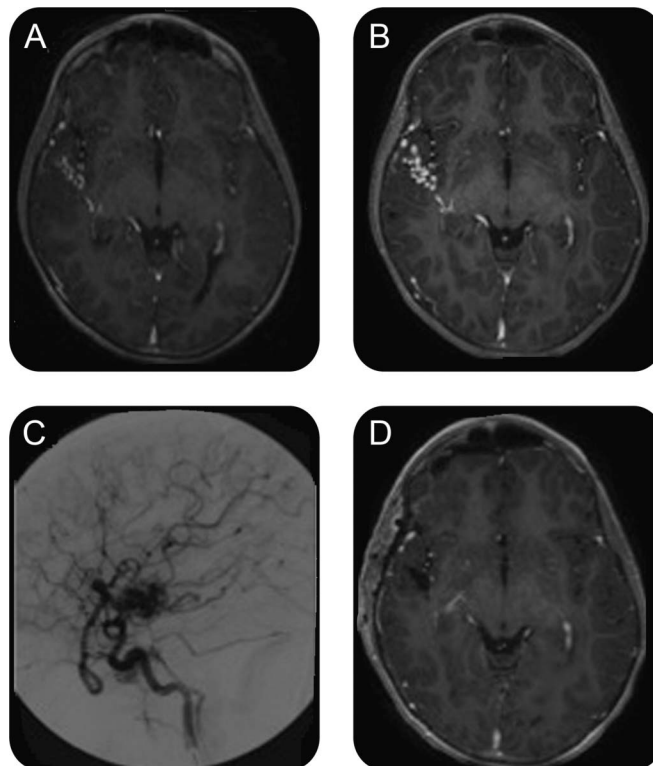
Initial MRI at the time of medulloblastoma treatment
